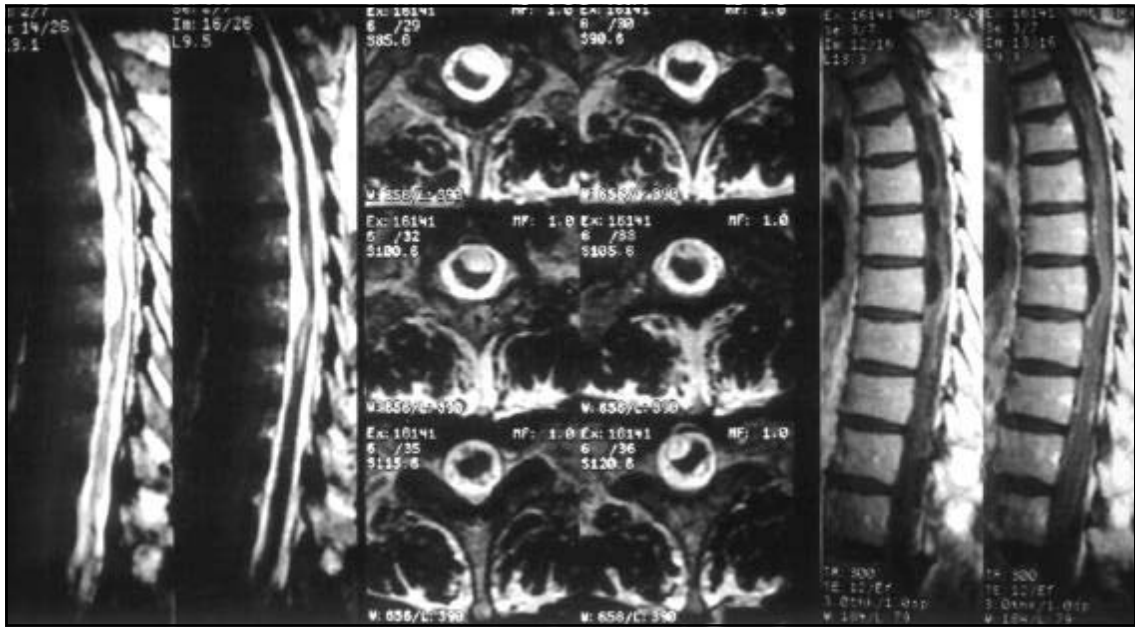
MRI Sagittal T2WI, Axial T1WI and Sagittal T1WI postcontrast (Gd-DTPA): Multiple cystic lesions in intradural-extramedullary situation leading to spinal cord compression.
